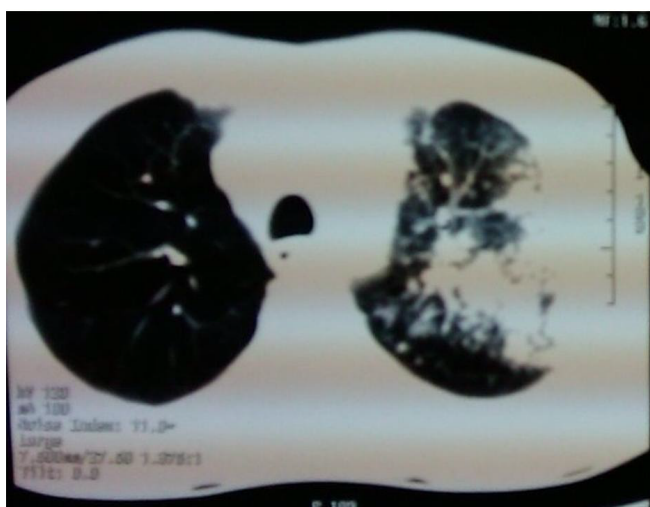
CT scan of thorax showed parenchymal opacity and infiltration in left lung
